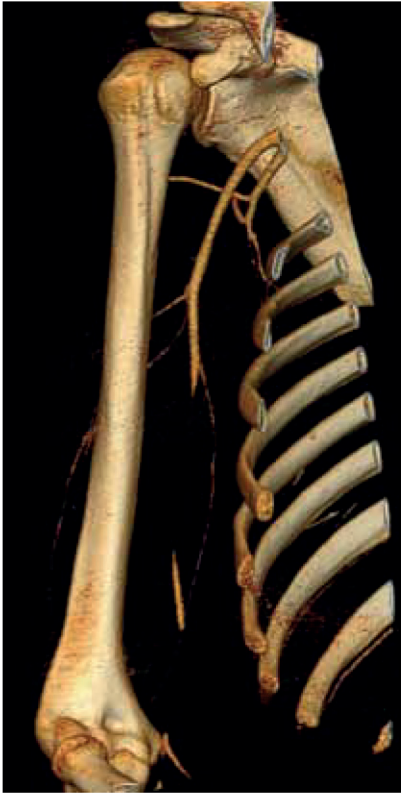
Computed tomography angiography of a patient without peripheral pulses on physical examination, showing an occlusion of the brachial artery, which was subsequently surgically reconstructed with venous interposition grafting.
